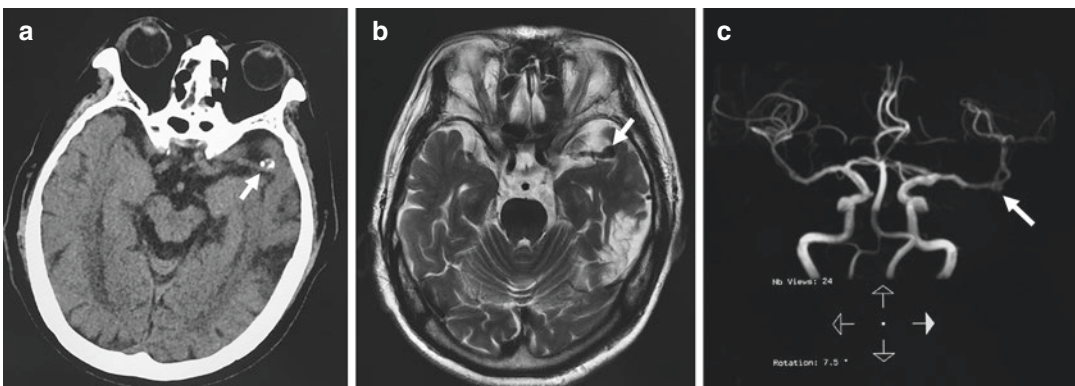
An 84-year-old woman presented with an incidental middle cerebral artery bifurcation aneurysm. (a) CT scanning showing a hypertensive mass in the left Sylvian fissure, which suggested a calcification (arrow). (b) Axial view of the T2-weighted MR imaging showing
